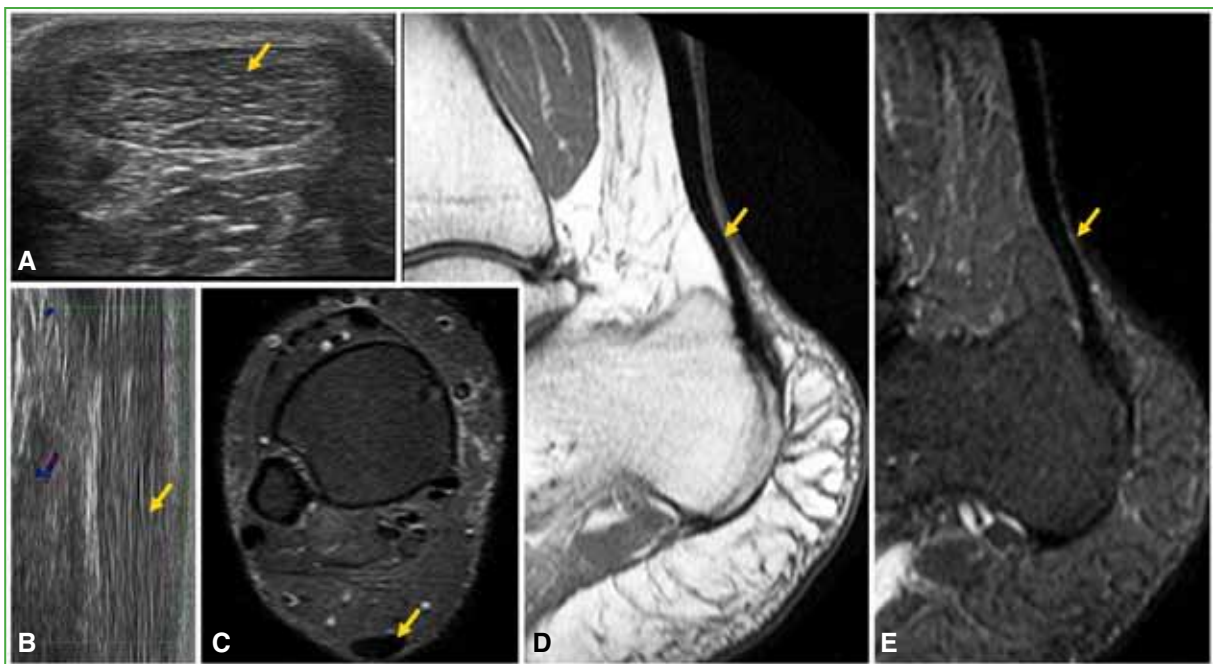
Normal Achilles tendon on both short (A) and long (B) axis ultrasound and magnetic resonance imaging in axial STIR (C), sagittal T1 (D), and STIR (E) sequences.
